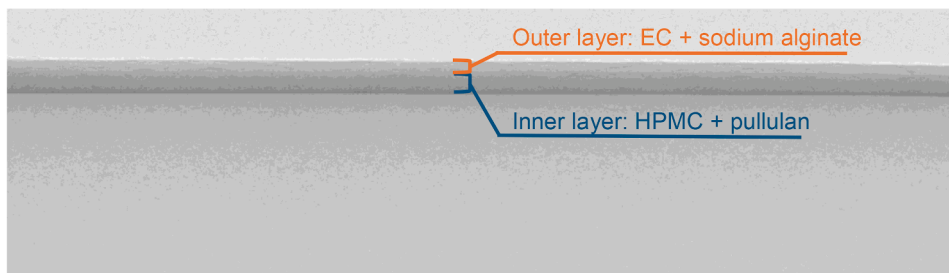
X-ray image of the capsule shell clearly displaying the two distinct layers.
